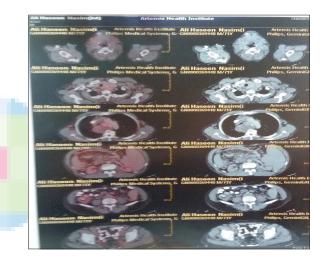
Whole body positron imaging tomography-computed tomography reveals splenomegaly with multiple enlarged faintly avid fludeoxyglucose avid cervical, axillary, mediastinal, retroperitoneal, pelvic and inguinal lymph nodes. There is also large heterogeneously enhancing multinodular left lobe of thyroid, extending into the mediastinum in the retro tracheal space, displacing the trachea to the right, reaching almost up to the level of the carina
